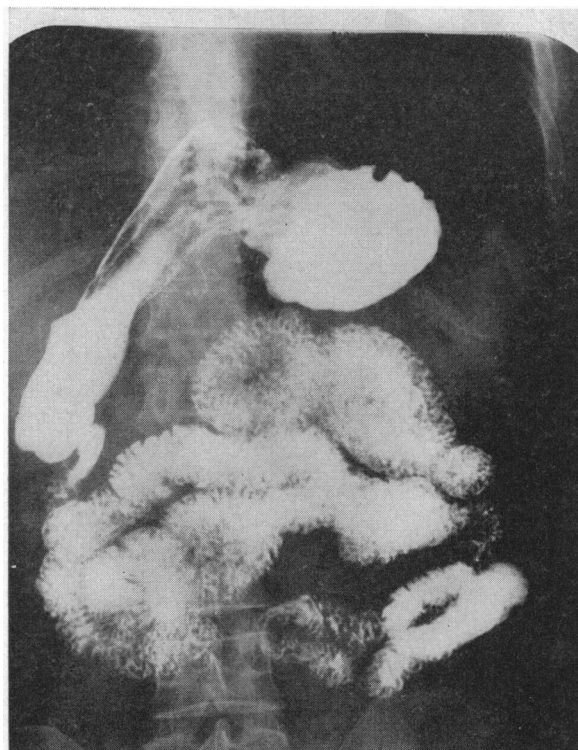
\*—Preoperative x-ray film. Note the greater curvature located above the lesser curvature.
